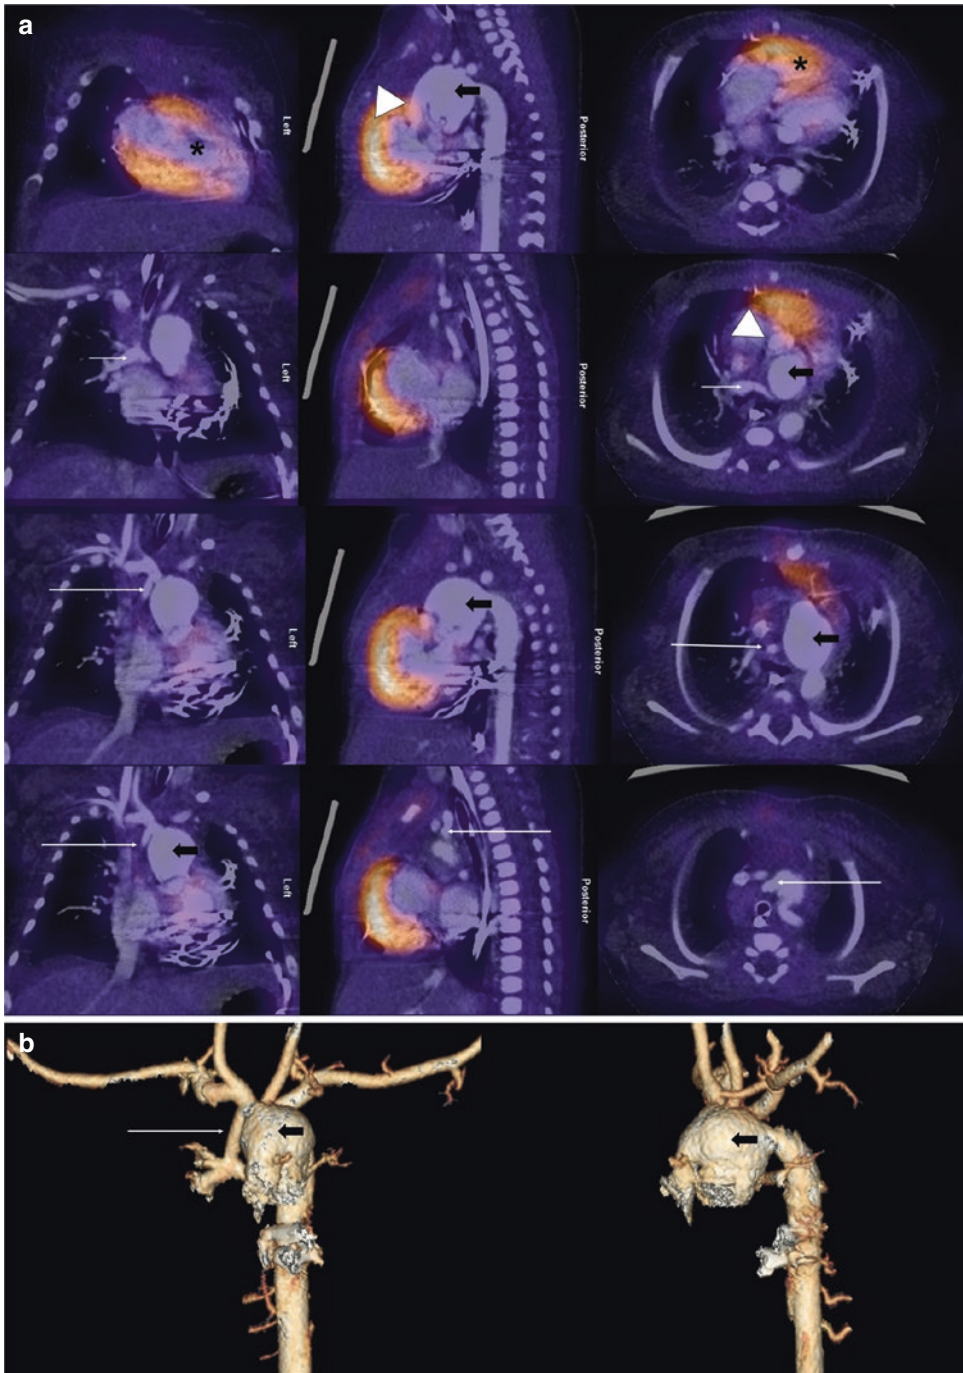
^{18}F -FDG PET/CT of a 1-month-old patient with left ventricle hypoplasia (*). ^{18}F -FDG CTAC images were fused with cardiac CT with contrast (a) and three-dimensional cardiac CT reconstructions (b). Norwood procedure with a Blalock–Taussig (BT) shunt (long thin
